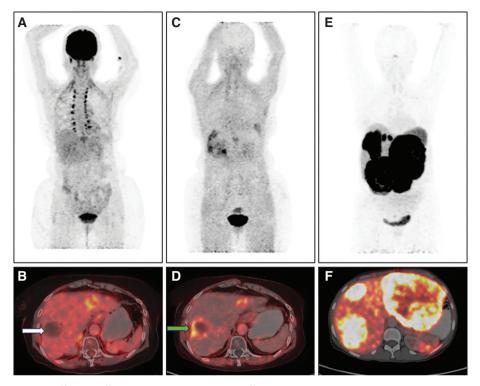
¹⁸F-FDG, ⁶⁸Ga-FAPI PET/CT in HCC and ⁶⁸Ga-DOTANOC PET/CT in NET. A. Maximum Intensity Projection (MIP) image of ¹⁸F-FDG PET/CT showing increased tracer uptake in the left lobe of liver in a case of HCC. Corresponding fused ¹⁸F-FDG PET/CT (B) image shows a non-FDG avid lesion in segment VII of liver (white arrow) and FDG avid lesion in left lobe. C. MIP image of ⁶⁸Ga-FAPI PET/CT in the same patient showing areas of increased FAPI uptake in both lobes of the liver with corresponding fused transaxial ⁶⁸Ga-FAPI PET/CT (D) image showing FAPI avidity (SUVmax 9.8) in the same segment VII and left lobe liver lesions (green arrow). ⁶⁸Ga-FAPI PET can detect more lesions with higher tracer uptake compared to ¹⁸F-FDG PET-CT in HCC. E. MIP image of ⁶⁶Ga-DOTANOC PET/CT in another patient with neuroendocrine tumor showing intense tracer uptake in the liver in multiple areas. Corresponding fused axial PET/CT image (F) shows intensely somatostatin receptor expressing lesions in both lobes of the liver, consistent with metastatic NET. ⁶⁸Ga-DOTANOC PET/CT is highly specific for neural crest origin tumors.
